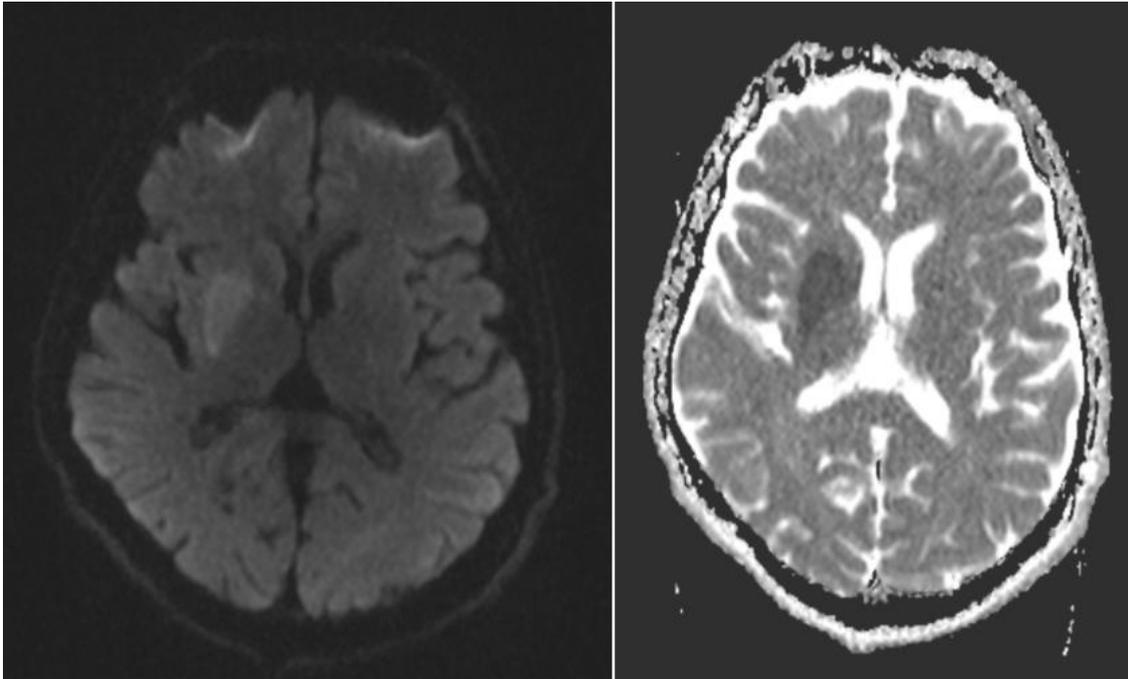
The patient's cranial magnetic resonance image
